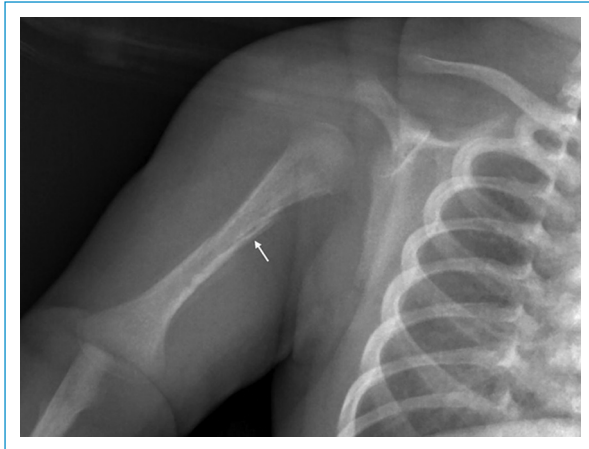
Anteroposterior radiograph showing signs of pandiaphysitis of the right humerus, with irregular periostitis and possible cortical rupture.
